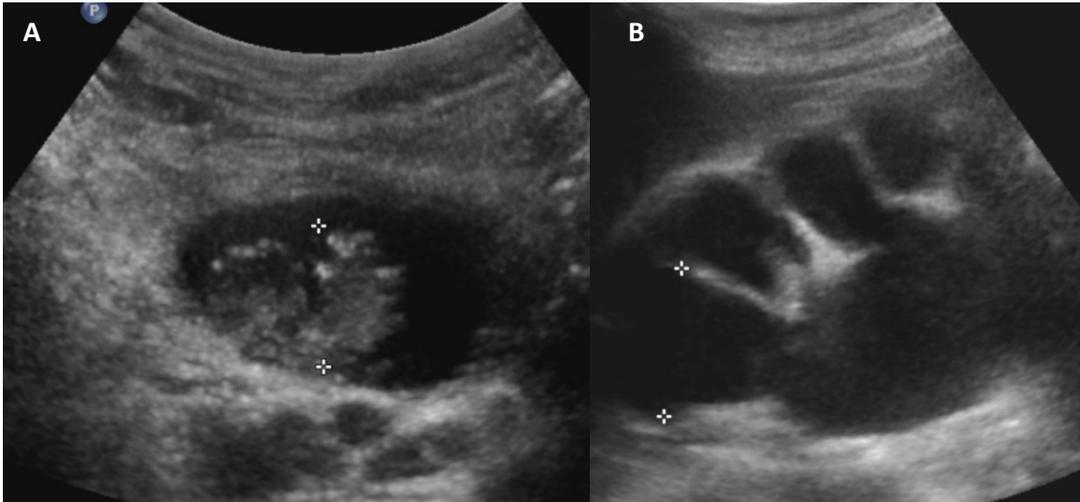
A - Ultrasound - urinary bladder tumor
